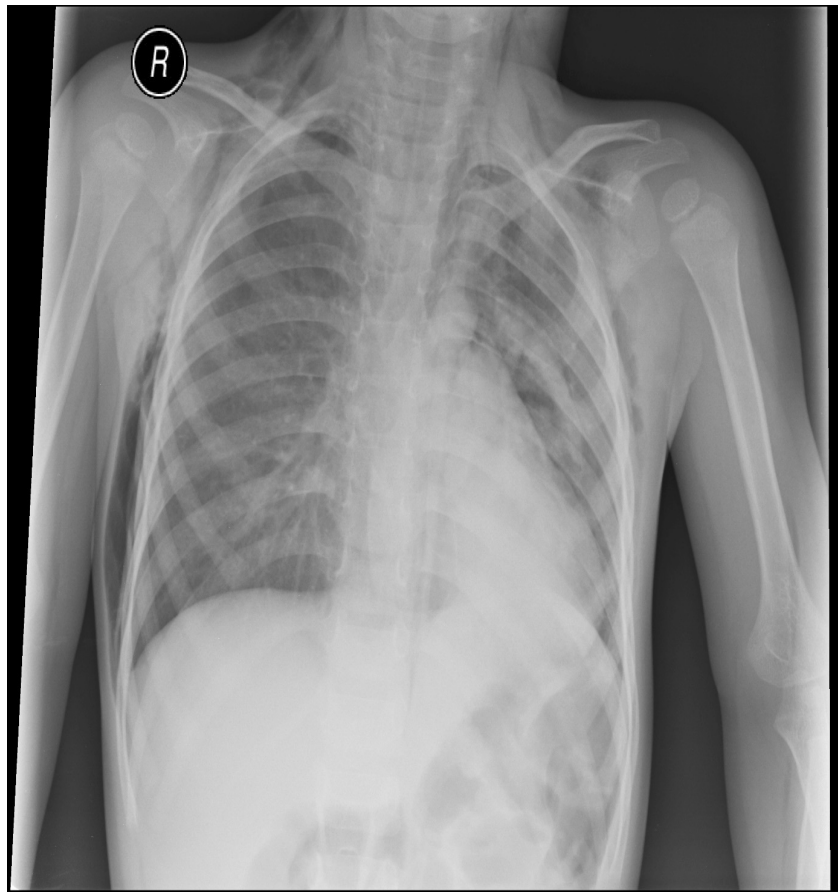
Second chest X-ray of the patient
